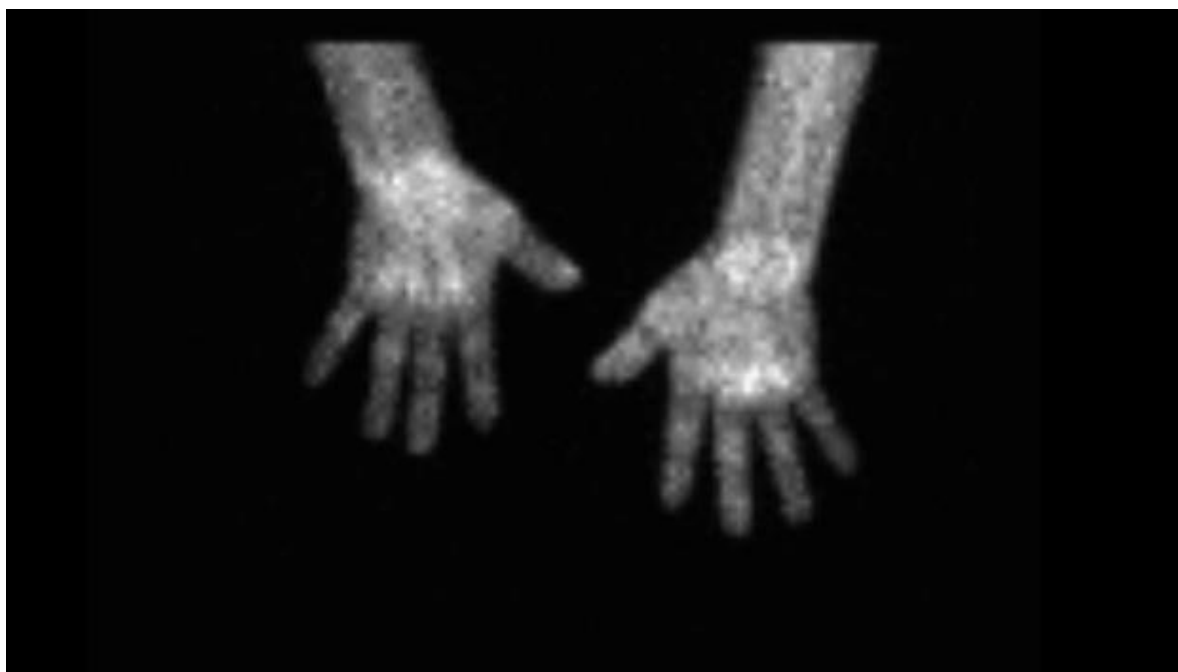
Bone scintigraphy using  $^{99m}\text{Tc}$  that shows uptake of the radioactive tracer in wrists and metacarpophalangeal joints.
